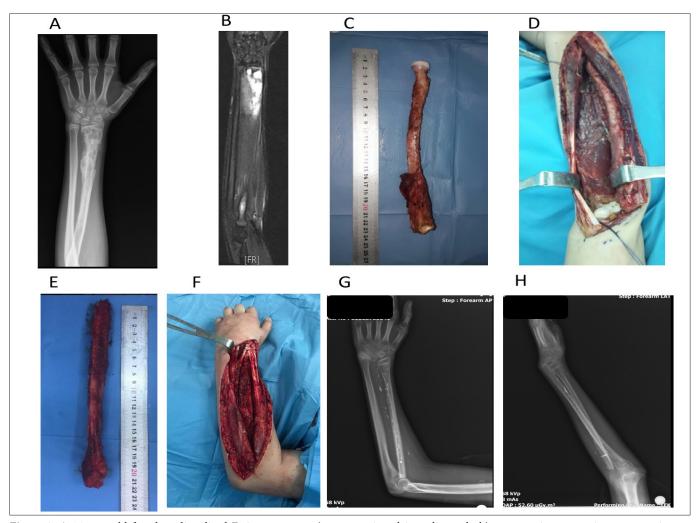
A 14-year-old female radius distal Ewing sarcoma, a) preoperative plain radiograph, b) preoperative magnetic resonance image, c,d,e,f) the patient had wide resection and biological reconstruction with osteoarticular vascularized fibular head graft, g,h) postoperative plain radiograph.
